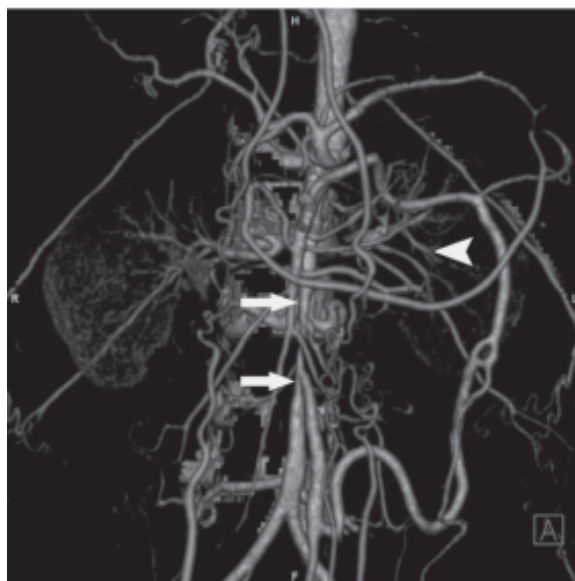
Computed tomogram angiography shows severe stenosis of the abdominal aorta at the levels of L2-3 and bilateral proximal renal arteries (arrows), consistent with mid aortic syndrome (MAS). There were multiple collateral vessels to supply the distal aorta, femoral arteries and renal arteries (arrowhead).
